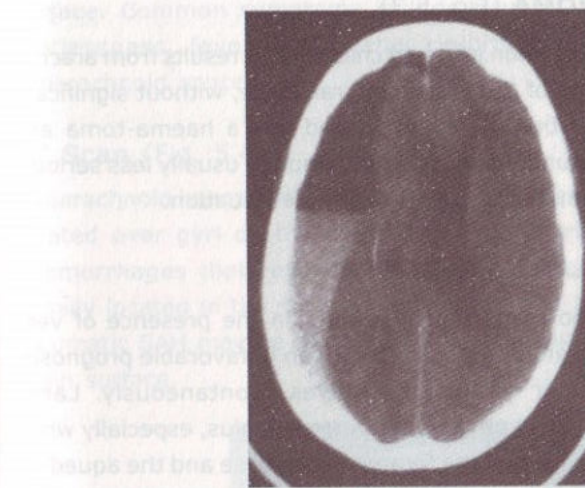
Characteristic CT scan of chronic subdural haematoma
